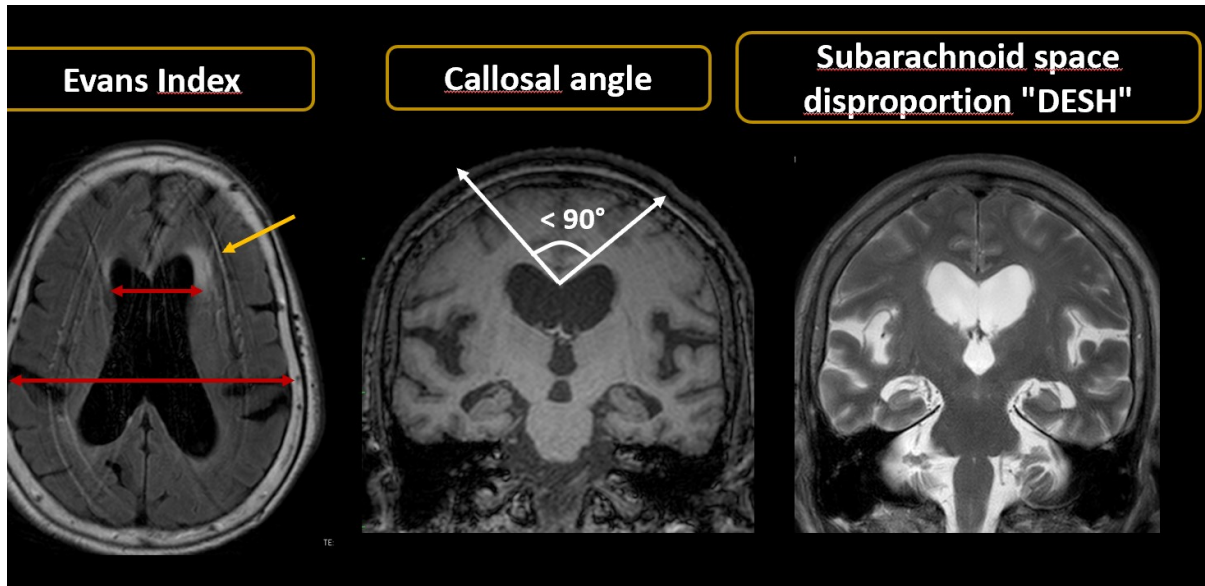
MRI image (left) shows Evan's Index measurements (red arrows), periventricular signal changes (orange arrow); MRI image (center) shows callosal angle; MRI image (right) shows flattened gyral tips against inner surface of skull
